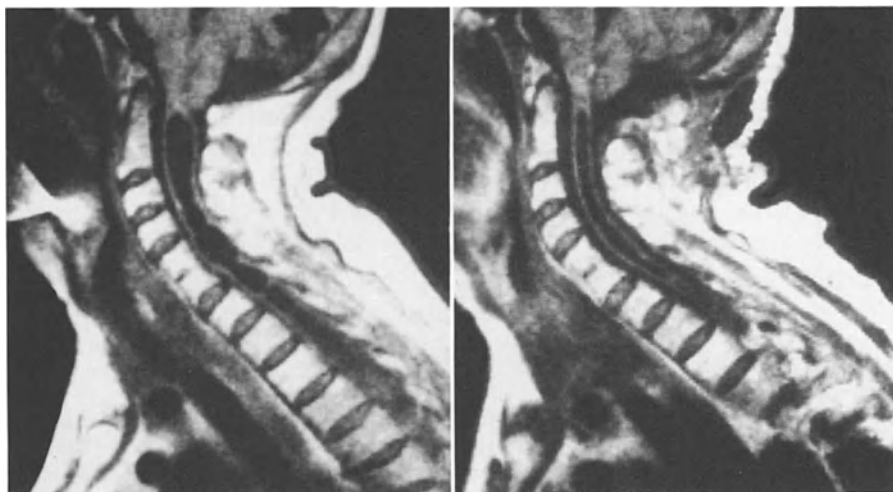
MRI before and 10 days following the operation in a 71-year-old female
